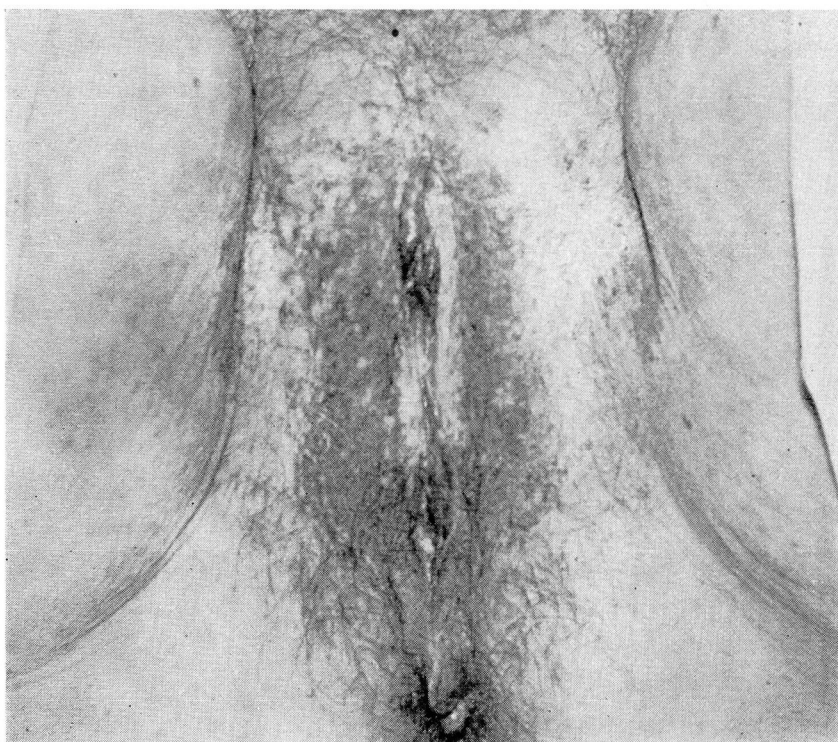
Radiodermatitis following roentgen therapy for pruritus vulvae. Case 4.
